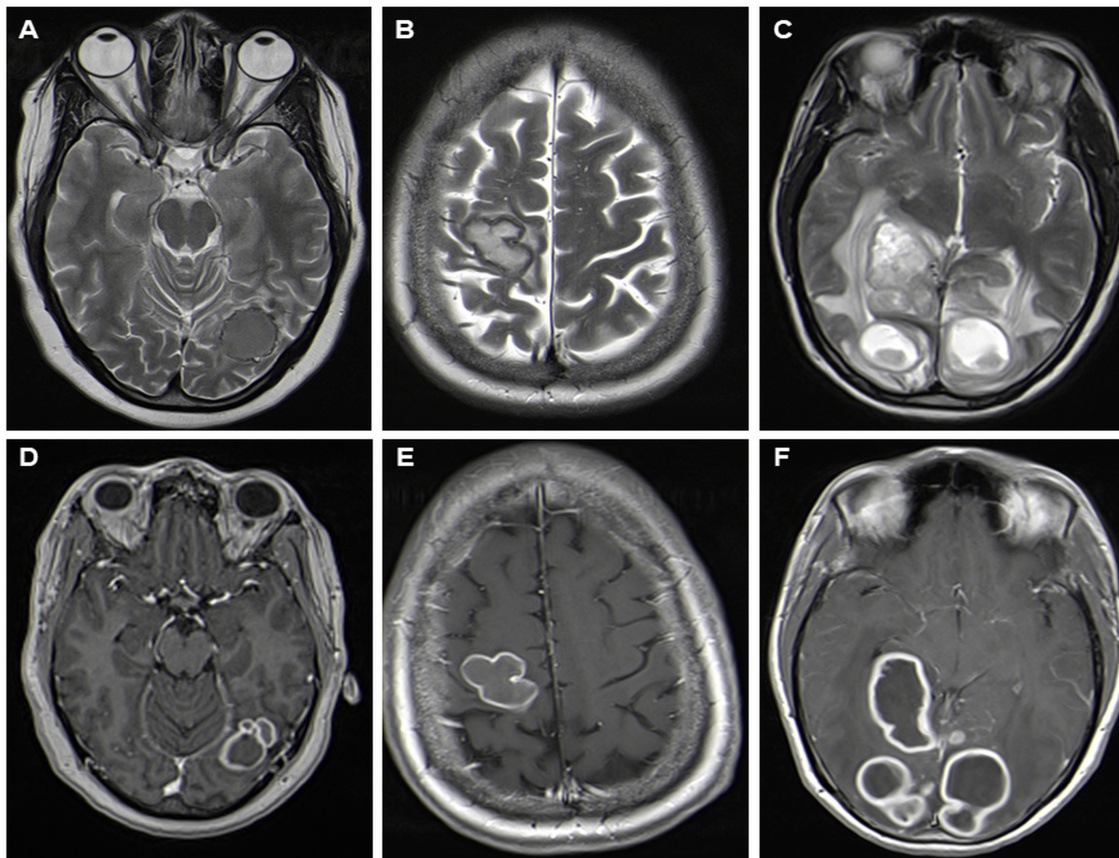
Magnetic resonance imaging of various categories of tuberculous mass lesions. Axial T2-weighted images (A, B and C) and corresponding T1-weighted post-contrast images (D, E and F) of caseating solid tuberculoma (A and D), caseating liquid tuberculoma (B and E) and tuberculous abscess (C and F).
